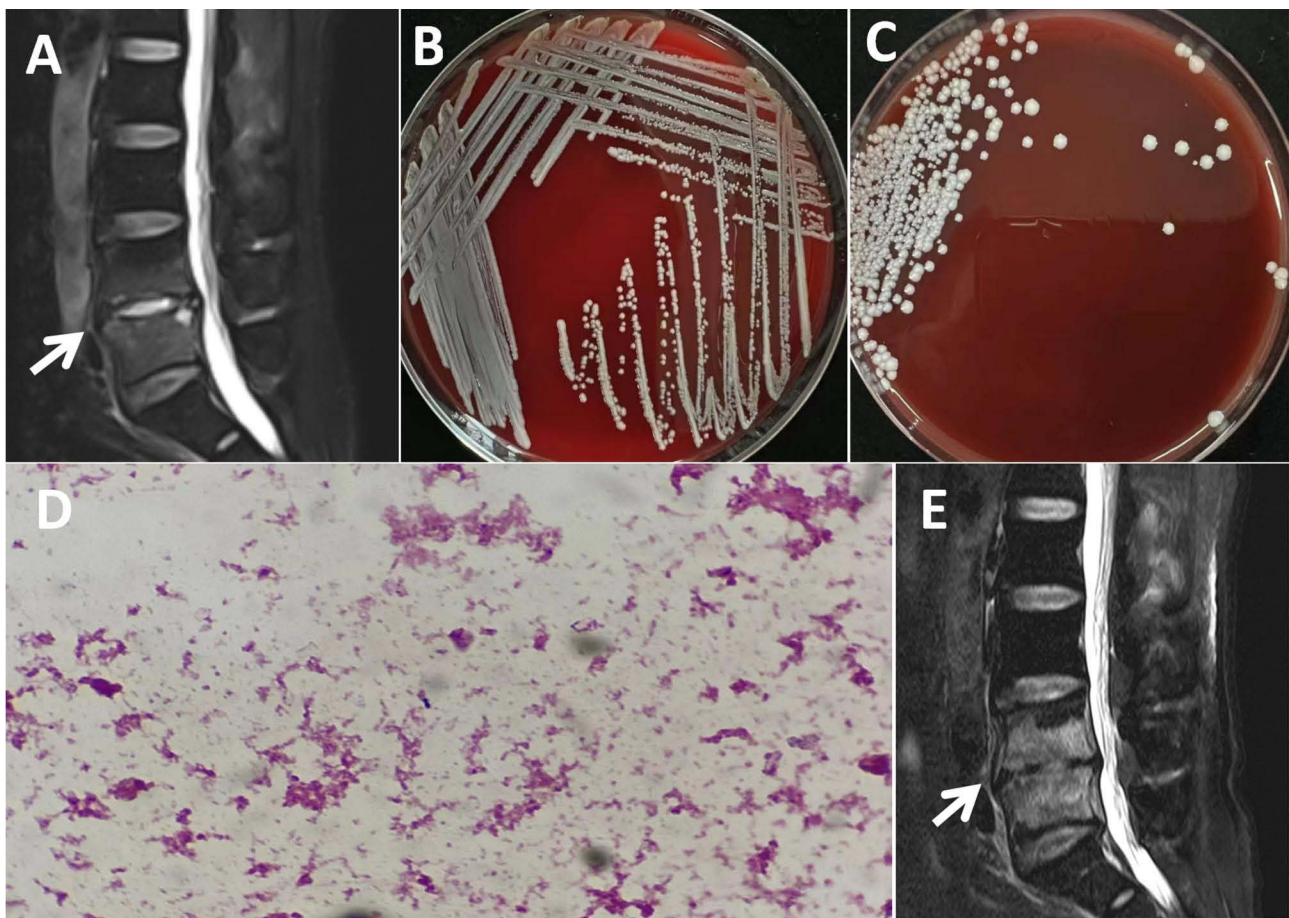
Representative results of MRI and sample culture. (A) T2-WI-FS image for diagnosis before antibiotic treatment (white arrow). (B) After 2 days of incubation, tiny, nonhemolytic, and milky white colonies were observed on the Columbia blood agar plate of blood samples. (C) After 2 days of incubation, tiny, nonhemolytic, and milky white colonies were observed on the Columbia blood agar plate of tissue samples. (D) Morphology of the tissue smear. (E) MRI reassessment 68 days after presentation (white arrow).
